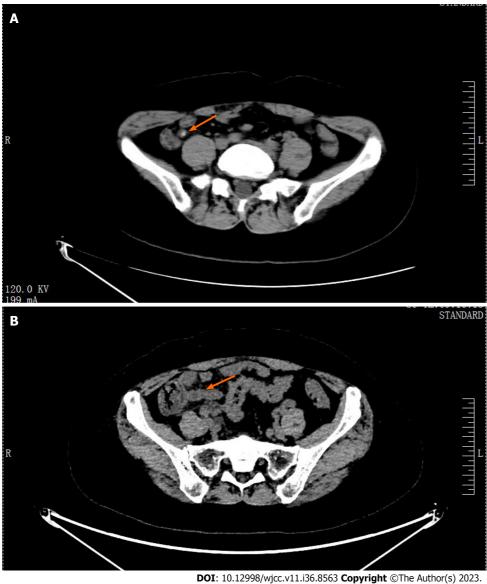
Computed tomography scan of the lower abdomen and pelvis. A: Computed tomography (CT) revealed a dilated and thickened appendix with fecoliths (solid arrow: Appendix with fecoliths); B: After 3 d of treatment, the pelvic CT revealed that the appendicolith had disappeared (solid arrow: Dilated appendix without fecolith).
